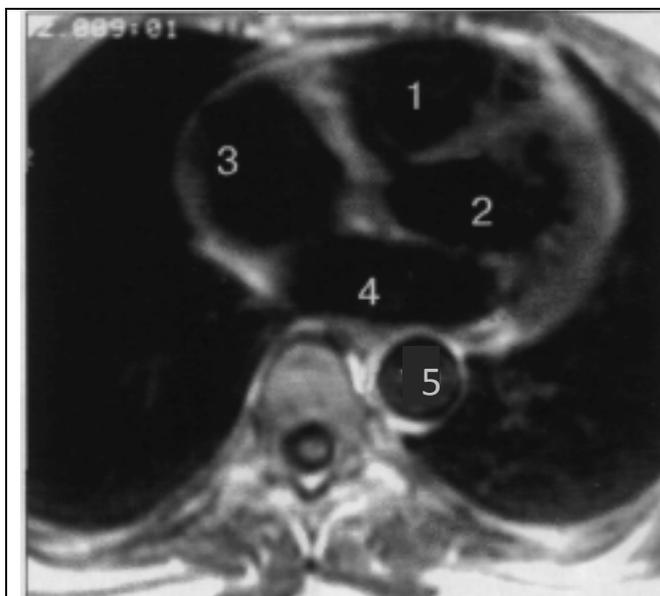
MRI (T1 -WI) of the chest at the level of Th VII vertebra. 1 - right ventricle, 2 - left ventricle, 3- right atrium, 4 - left atrium, 5- descending aorta.
